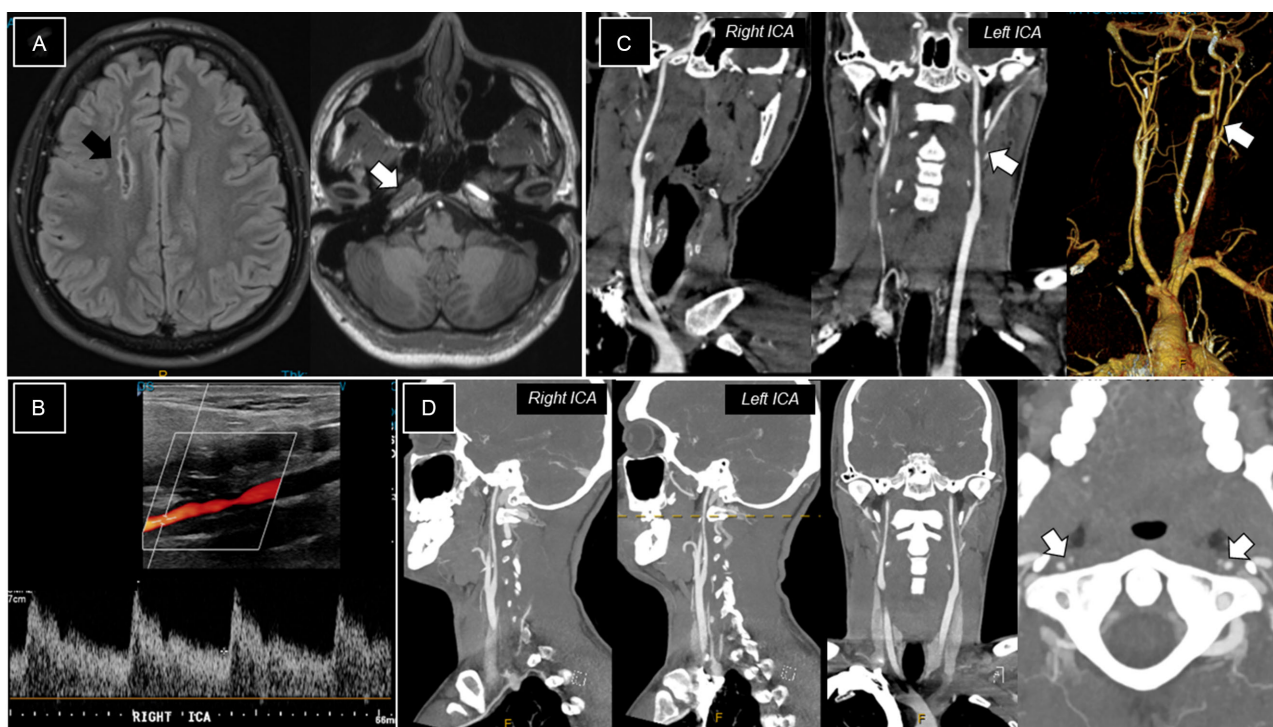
(a) MRI of the brain demonstrating a chronic right cerebral watershed infarct on fluid-attenuated inversion recovery images [black arrow] and loss of the normal bright vascular signal in the right ICA on T1-MPRAGE images [white arrow]. (b) Right carotid ultrasound four weeks later showed broadening of the spectral waveform and “beading” of the distal right ICA. (c) CTA after another week revealed a focal critical stenosis of the left ICA with a normal-appearing ICA on the right. (d) Resolution of left ICA stenosis on repeat CTA after six weeks, with diffuse narrowing of both ICAs.
